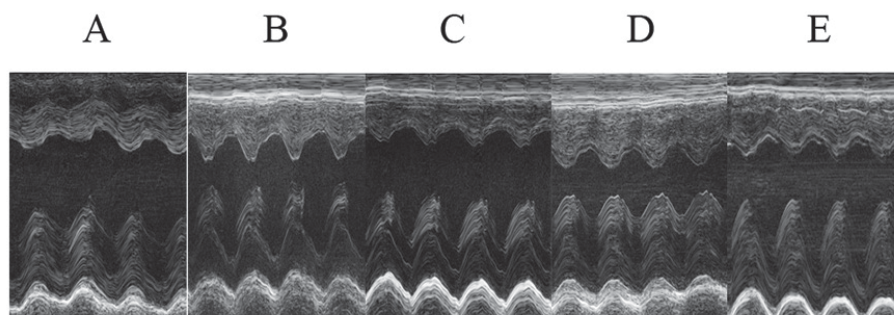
Cardiac ultrasonography results (n=5 for each group). (A) PTH-untreated cardiomyopathy, (B) normal control, (C) 5 μg/kg PTH, (D) 10 μg/kg PTH and (E) 20 μg/kg PTH groups were indicated. PTH, parathyroid hormone.
